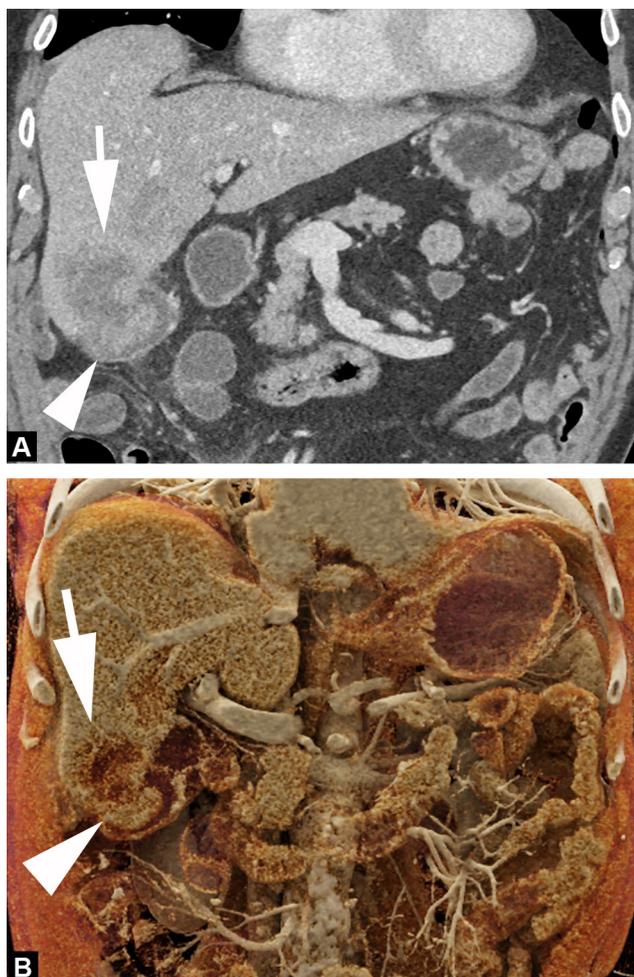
A 79-year-old man with history of metastatic colon cancer. A. Two-dimensional CT image obtained in the coronal plane during the portal venous phase of enhancement shows a heterogeneously enhancing liver metastasis in the right liver (arrow) with direct invasion into the gallbladder (arrowhead). B. CT image obtained in the coronal plane during the portal venous phase of enhancement with cinematic rendering can improve depth perception and increase appreciation of tumor invasion (arrow) into the gallbladder lumen (arrowhead).
